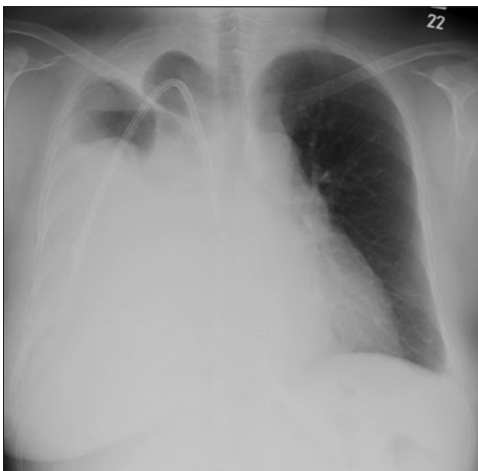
Chest radiograph in patient 1 showing right-sided pleural effusion at presentation
